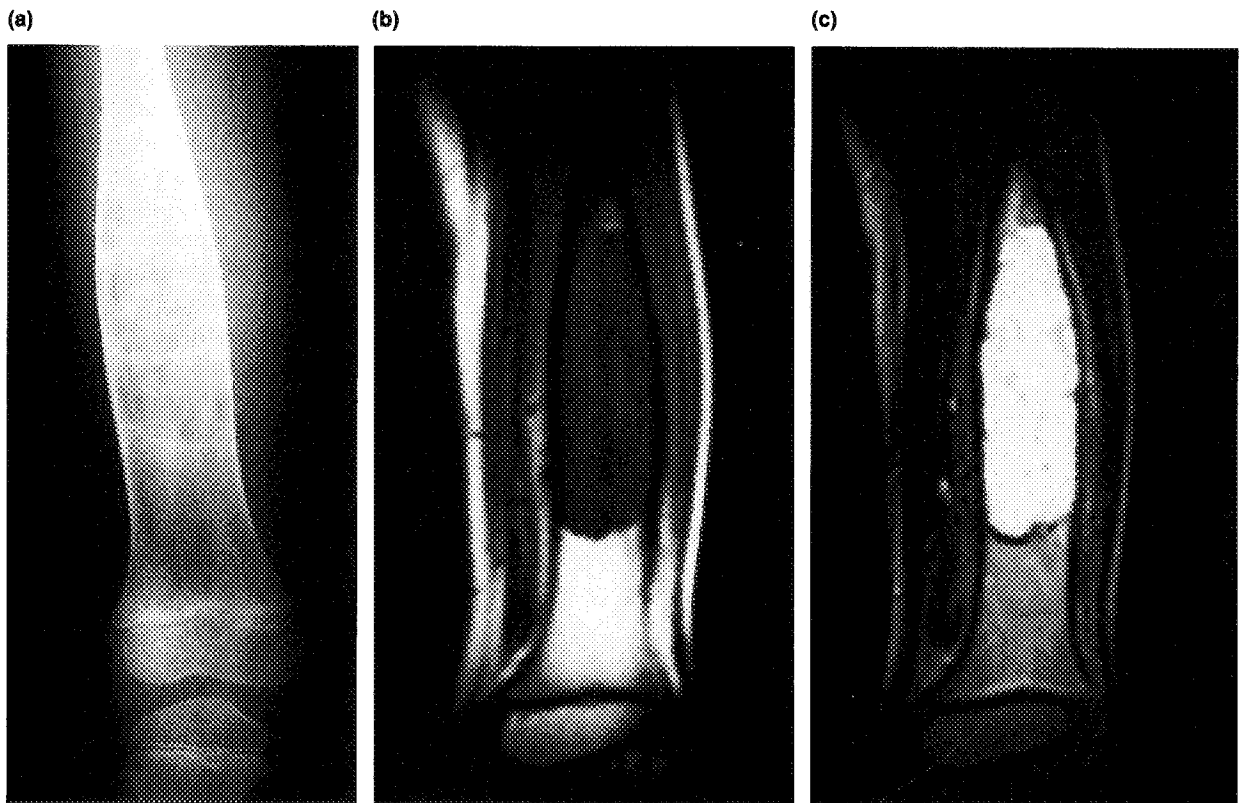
Case 8. Hazy radiopaque, expanded lesion of the midshaft of the left femur (a). The lesion shows low intensity in T1-weighted magnetic resonance (MR) image (b) and high intensity with lobulation in T2-weighted MR image (c).
